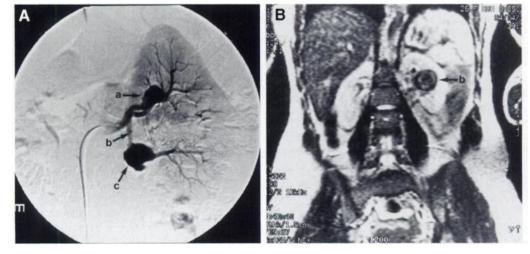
(A) Two saccular aneurysms (2- and 2.5-cm, respectively) are demonstrated angiographically in the left kidney (a, c). Thrombosis of a segmental artery with collateral circulation and mass effect is found in the middle third (b). (B) Coronal T2-weighted MR image of the left kidney demonstrates a 4-cm partially thrombosed calcified saccular aneurysm (b).
